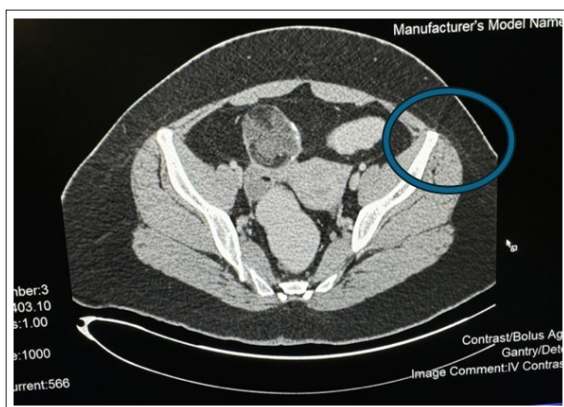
A complex mixed attenuating mass at the right adnexal region seen on CT scan in 2019
